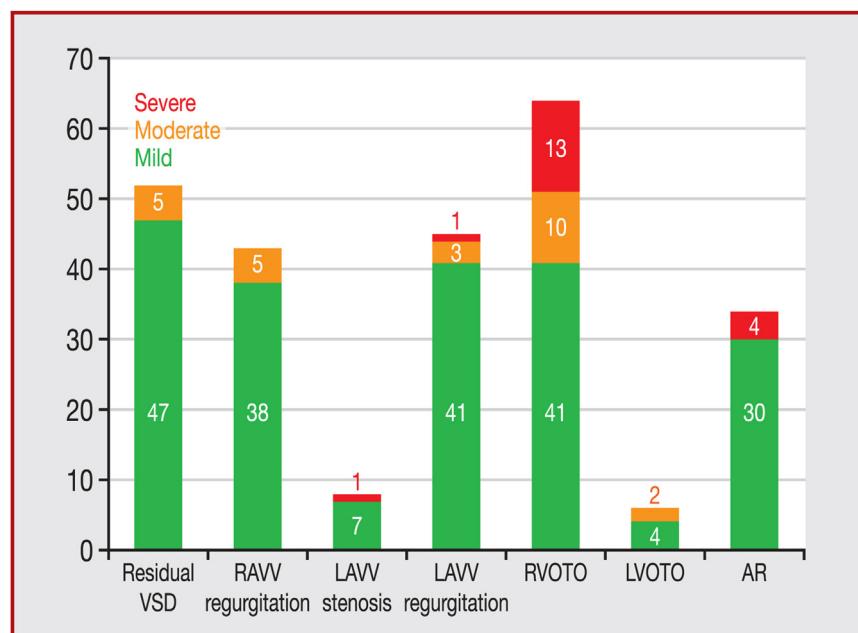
Classification of residual lesions seen on perioperative transoesophageal echocardiography, and their severity. AR: aortic regurgitation; LAVV: left atrioventricular valve; LVOT: left ventricular outflow tract; LVOTO: left ventricular outflow tract obstruction; RAVV: right atrioventricular valve; RVOT: right ventricular outflow tract; RVOTO: right ventricular outflow tract obstruction; VSD: ventricular septal defect.
